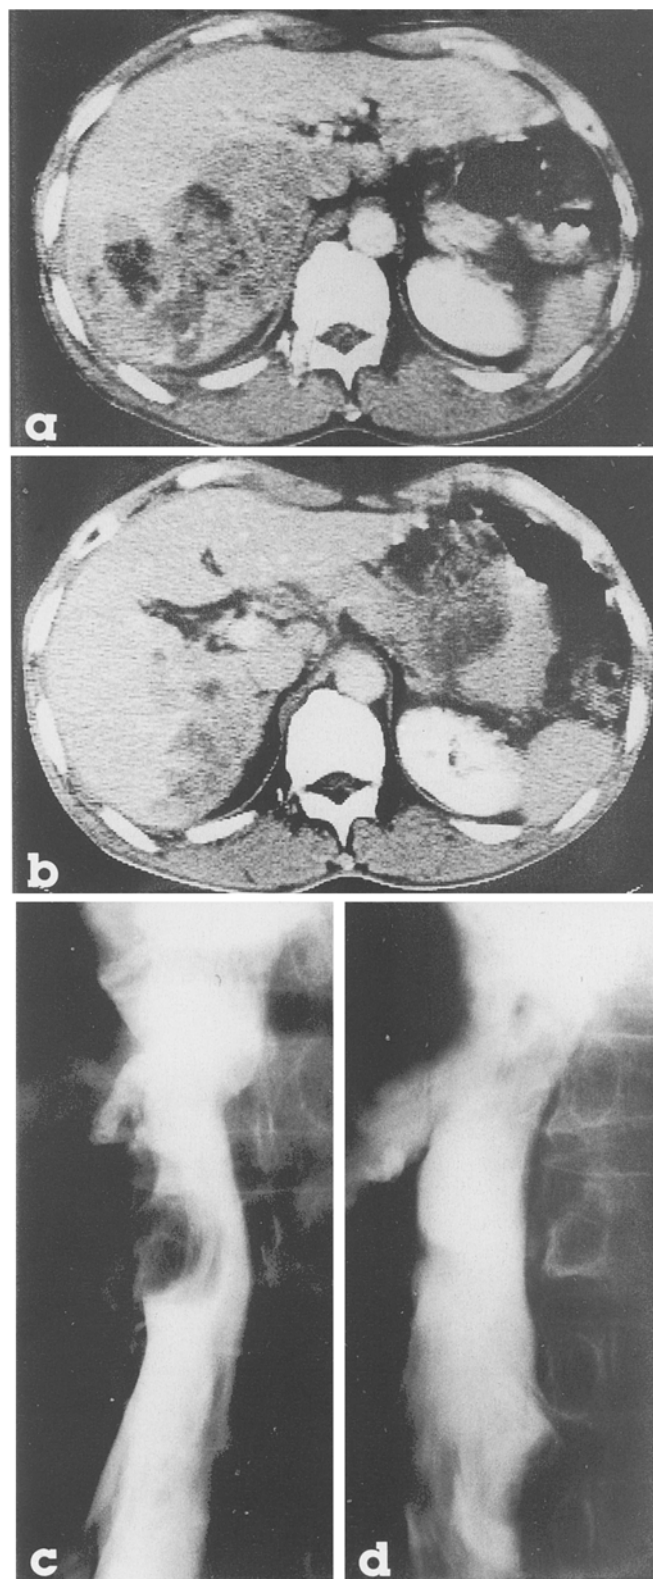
a–d. CT scans and cavograms obtained prior to and after EAP therapy in a 53-year-old man). a CT prior to EAP: a huge HCC is visible in the right lobe. b CT after EAP: the tumor has become very small (81% regression). c Cavogram prior to EAP: a large filling defect in the IVC can be seen on the cavogram. d Cavogram after EAP: the filling defect has almost disappeared
